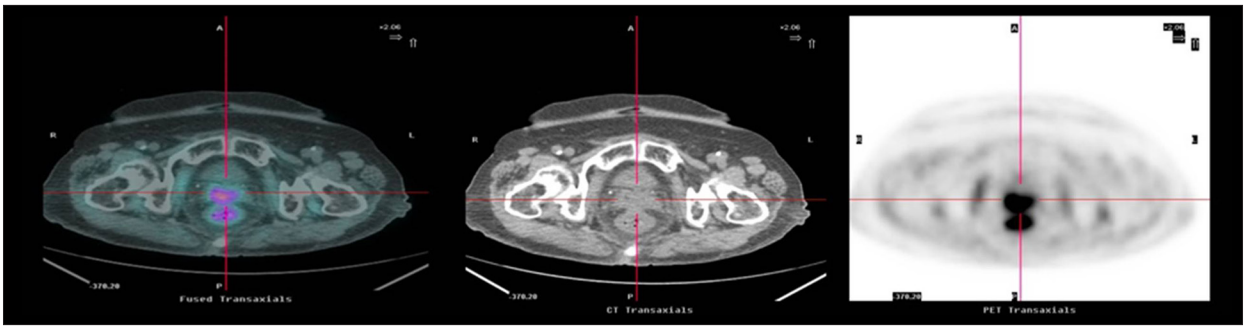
FDG-PET CT showing an early and late maximum standardized uptake value (SUVmax) of 4.59 and 6.34, respectively. These findings indicate central recurrent malignancy.
